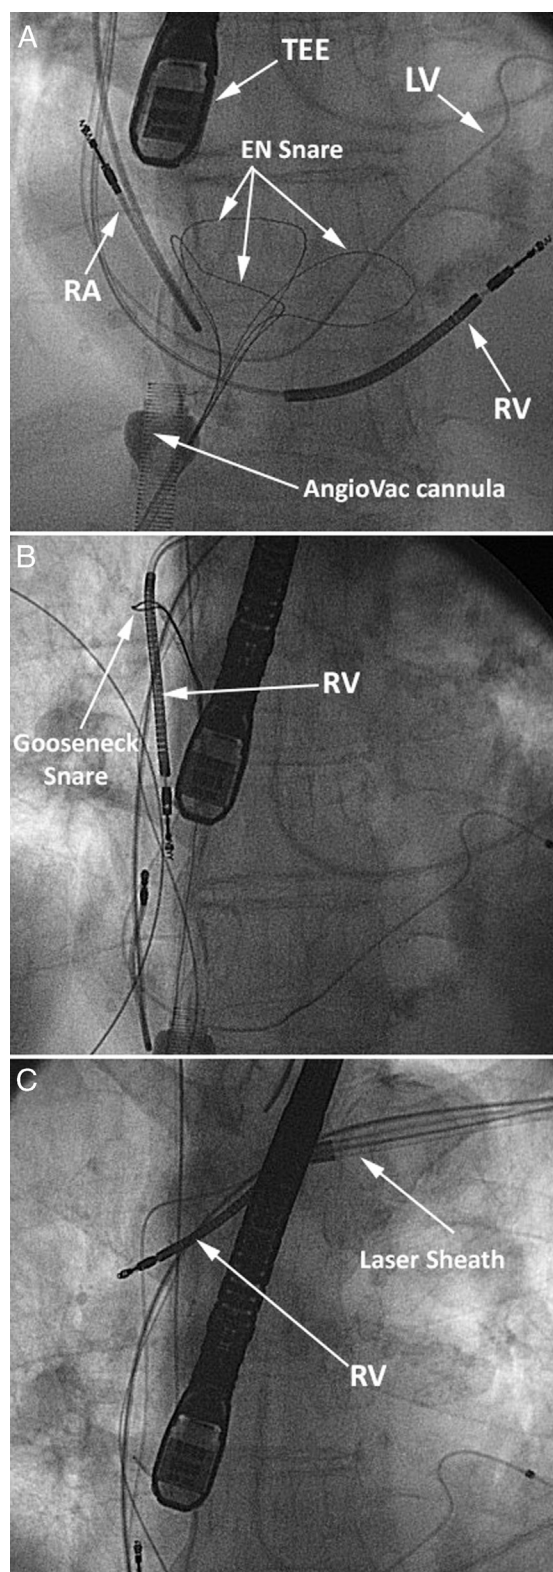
Fluoroscopy images (anteroposterior view) during simultaneous vegetation removal and lead extraction. A: The AngioVac cannula is positioned at the low right atrium (RA). The EN Snare is used to debulk the vegetation off the right ventricular implantable cardioverter-defibrillator lead (RV), under transesophageal echocardiography (TEE) guidance. B: Once the RV lead tip is freed with countertraction during laser extraction, a 20 mm gooseneck snare is used to "strip" the lead from attached vegetations. C: Lead extraction was completed while AngioVac suction was active. LV = left ventricular lead.
